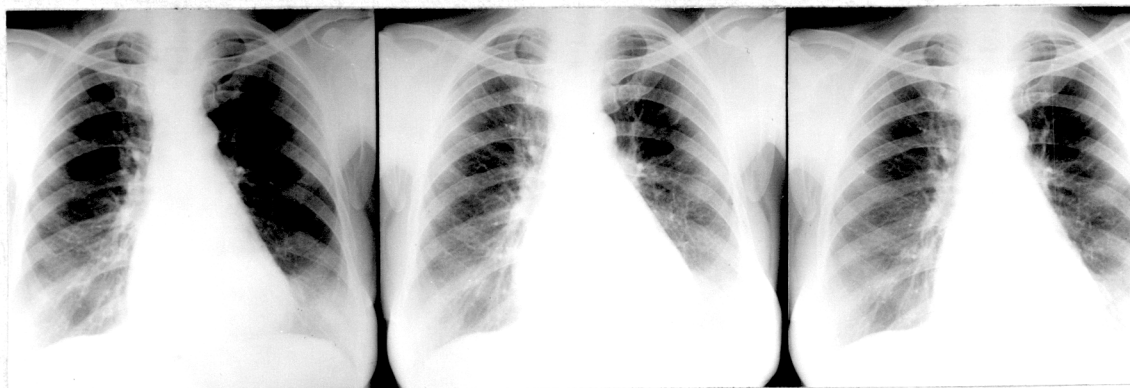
Chest radiograph of Patient number 142, 1 day before synchronised capacitor discharge on the left, 1 day after (middle) and 2 days after DC shock (right). Note the increase in the size of the heart 1 day after electrical conversion.
